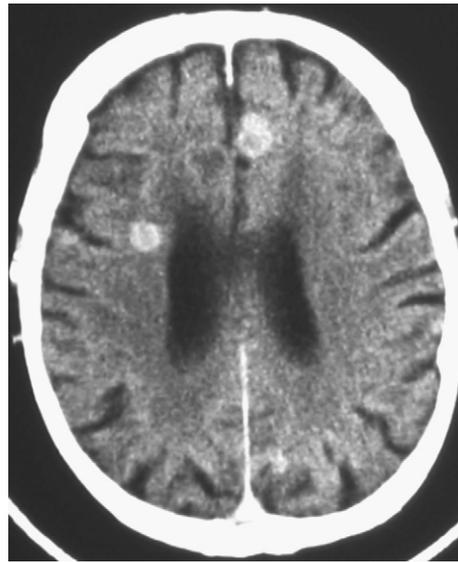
Cerebral histoplasmosis. Enhanced brain CT scan shows multiple ring-enhancing *Histoplasma* lesions.
